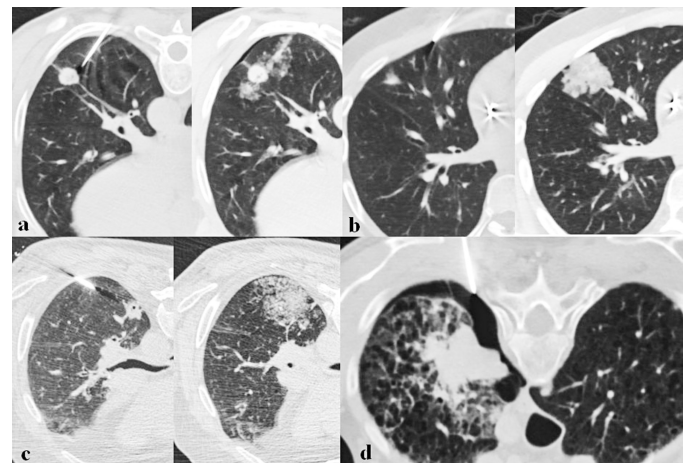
TTNB complications examples, CT images during procedure and after needle removal are shown. (a) Needle tract alveolar haemorrhage, (b) subsegmental bleeding, (c) segmental bleeding. (d) PTX during needle insertion, we would also like to draw attention to the narrow needle pleural angle in this case.
